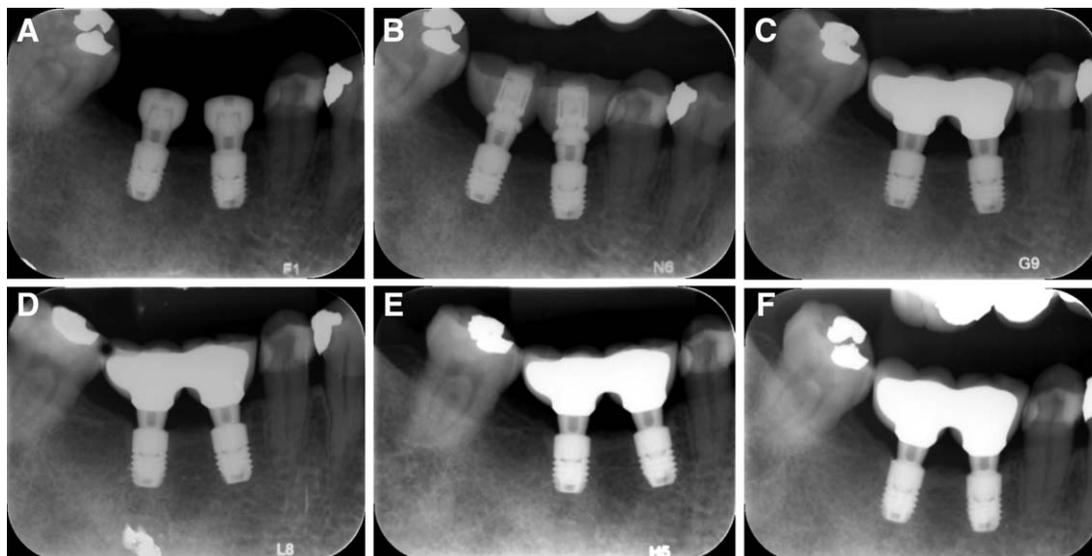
Radiographic documentation of A, OsseoSpeed implant, UniAbutment and Healing Cap after implant placement; B, at provisional prosthesis delivering (loading baseline); C, at definitive porcelain fused to metal prosthesis delivery (6 months after loading); D, at the 1-year follow-up; E, at the 2-year follow-up; F, at the 3-year follow-up
